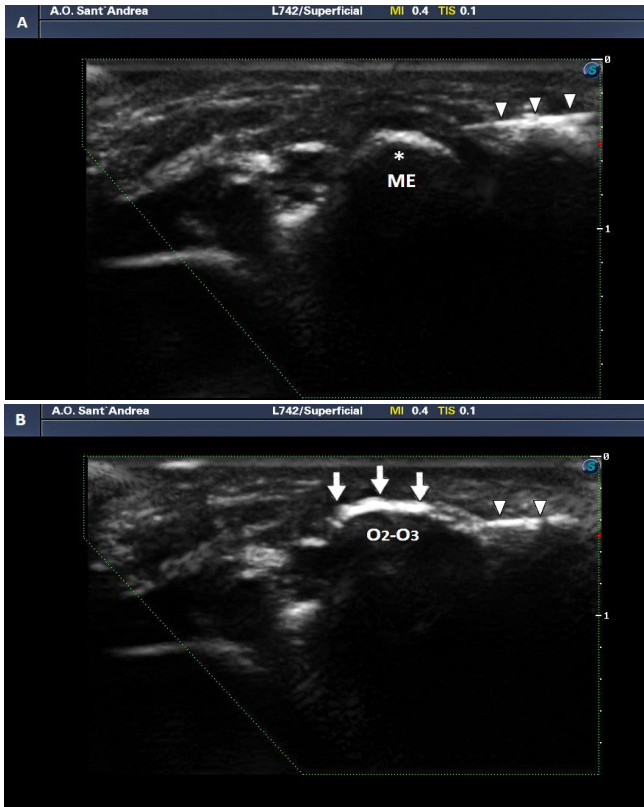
Medial epicondylitis ultrasound-guided infiltration.
